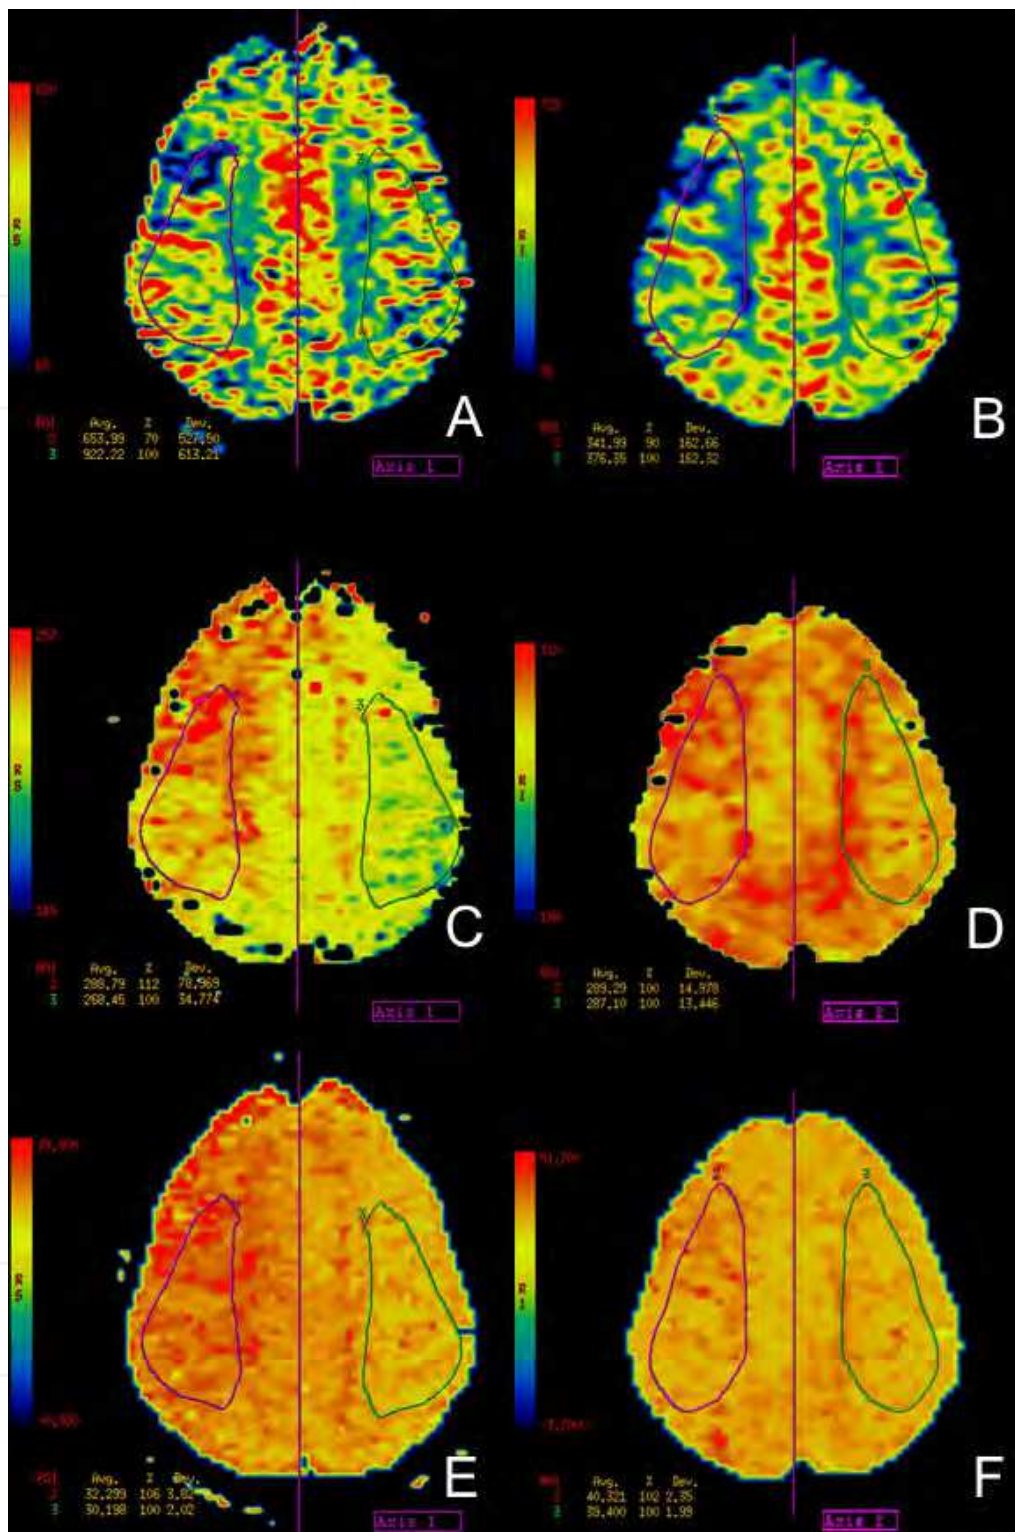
A 56-year-old patient with severe right cervical carotid artery stenosis evaluated by digital angiography (not shown). Perfusion by MRI was performed in a section above the lateral ventricles. Before carotid angioplasty, the cerebral blood volume (CBV) of the right ACM territory was reduced by 30% compared with the contralateral (A), the mean transit time (MTT) was delayed by 12% (C) and the time to peak (TTP) was delayed by 6% (E). In the same axial plane after CAS, perfusion studies show improved parameters: the right side CBV
